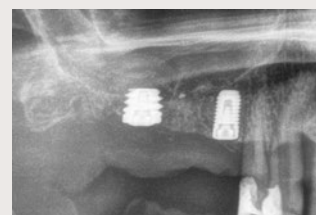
Postoperative radiograph showing the implant placed in position following transcresal elevation
